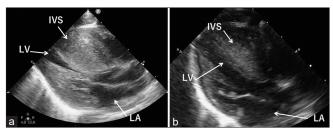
Echocardiograph of the neonatal heart. (a) Although cardiac contraction was adequate, myocardial hyperplasia and left ventricular outflow tract stenosis were observed on day 1. (b) Interventricular septal thickening was improved, and the left ventricular cavity was enlarged on day 19
